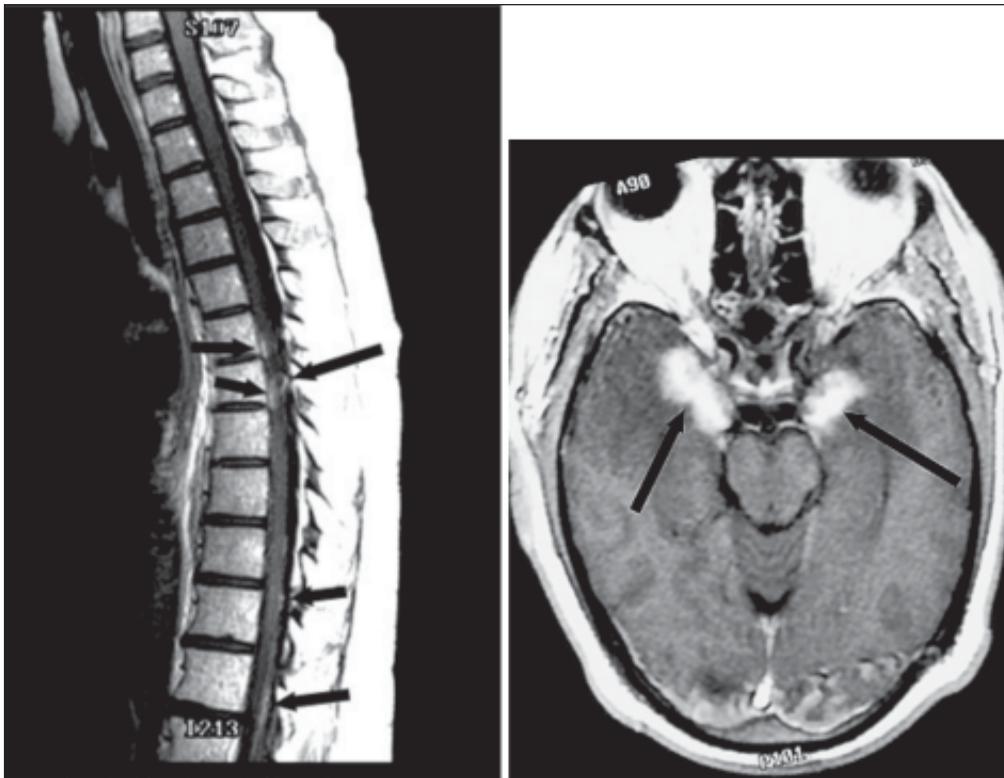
Sagittal contrast enhanced T1-weighted MR image of the spine shows pial enhancement (arrows) consistent with leptomeningeal spread of leukemia and positive CSF cytology.
